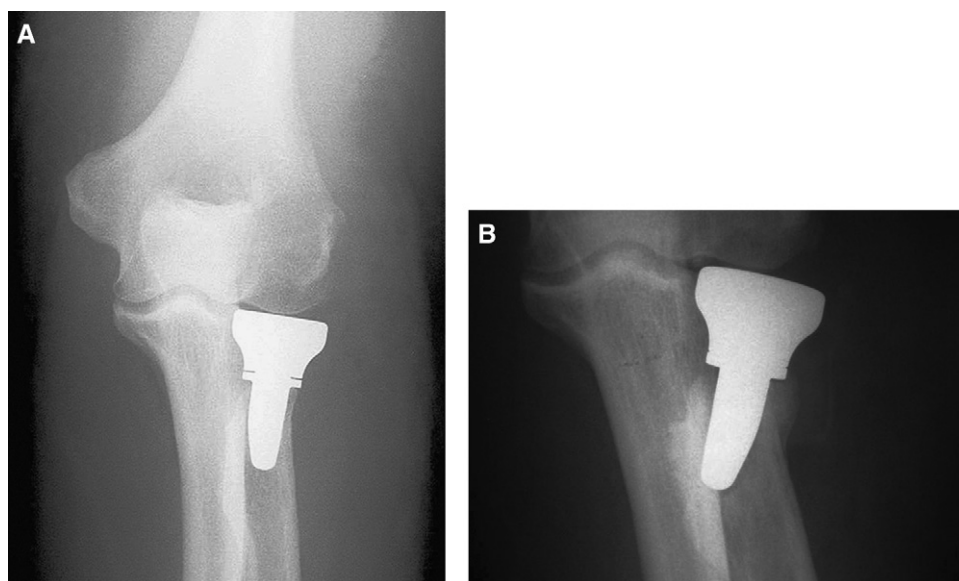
Radiographs of a 57-year-old man in whom proximal radial forearm pain developed from a loose radial head prosthesis. (A) Early postoperative radiograph showing Avanta rHead. (B) Radiograph taken 7 months postoperatively showing angular displacement of stem, bony reaction under the collar, and a lucent zone around the stem.
